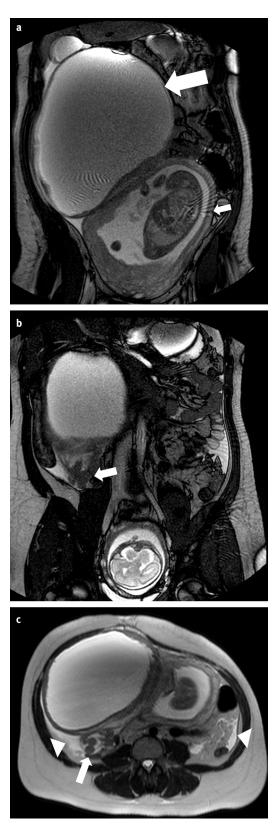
MRI in a pregnant patient showing right adnexal torsion. (a) and (b) Coronal balanced fast field echo images, (c) axial T2 weighted images. The patient has a right sided abdominal mass with a thick irregular wall and central fluid signal (large arrow in (a)) and abdominal free fluid (arrowheads in (c)), both of which had been detected on ultrasound. The known intrauterine pregnancy is also shown (small arrow (a)). An additional finding on MRI, not detected on ultrasound, was the twisted adnexal pedicle (arrows in (b) and (c)) connecting the uterus to the mass, confirming the diagnosis of adnexal torsion for which surgery in pregnancy was required
